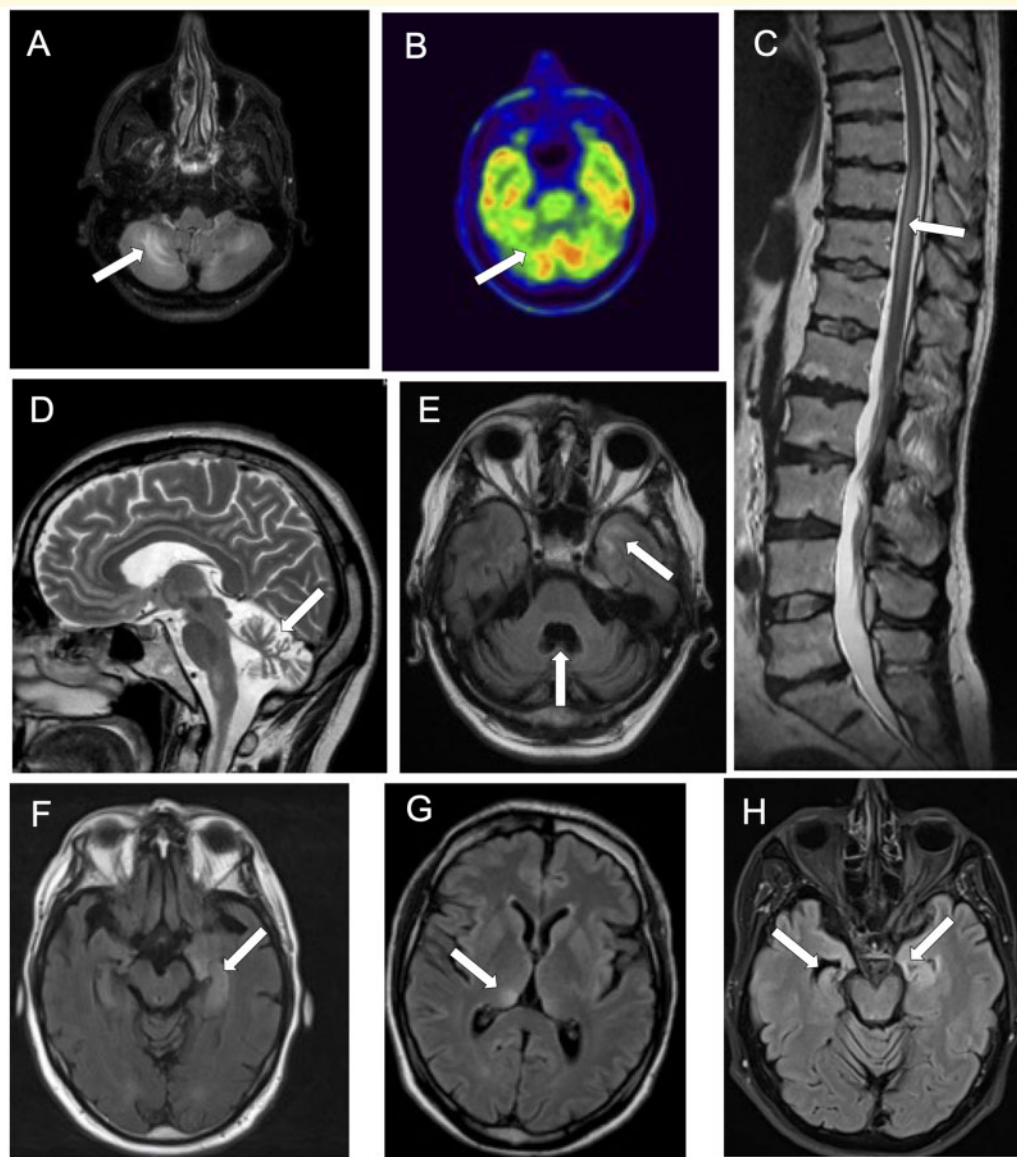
Neuroimaging findings in patients with KLHL11-Abs. Axial brain MRI (A), showing hypersignal asymmetrically involving both cerebellar hemispheres, colocalizing with an area of cerebellar hypometabolism on brain PET (B). Sagittal spine MRI showing spinal cord hypersignal in a patient with myelitis (C). Marked cerebellar atrophy is shown in both sagittal (D) and axial (E) brain MRI. The atrophy is more pronounced in the vermis and associates with an area of hypersignal involving the temporal lobe (E). Axial brain MRIs showing hypersignal involving the left mesial temporal lobe (F), the right thalamus (G) and coexistence of left mesial temporal lobe hypersignal and right hippocampal atrophy.
